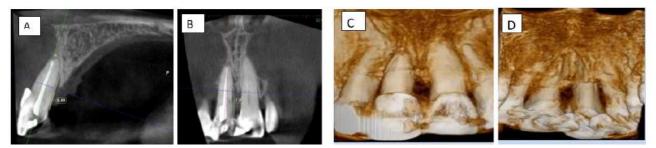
Six month Post operative CBCT: A) showed bone loss 8.49 mm sagittally B) showed bone loss 7.20 mm coronally C) Labial view D) Palatal view
